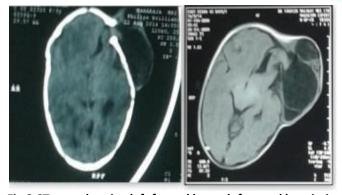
CT scan showing left frontal bony defect and herniation of brain mass and MRI showing left frontal bony defect and lesion causing indentation in brain parenchyma
